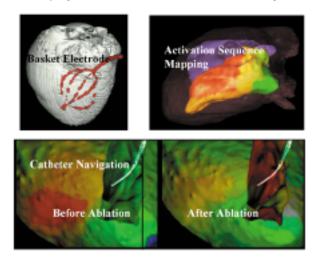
Procedure for image guided cardiac ablation using 4-D images of the heart obtained from 3-D dynamic CT and/or US scans. Images are fused on-line with electrophysiology recordings from basket electrodes (top left) to localize anatomic regions causing arrhythmia by observing functional activation sequences mapped onto myocardial walls (top right) and navigating to optimal position for focused-energy catheter ablation of the offending region (bottom left), returning cardiac cycle to normal sinus rhythm (bottom right).
